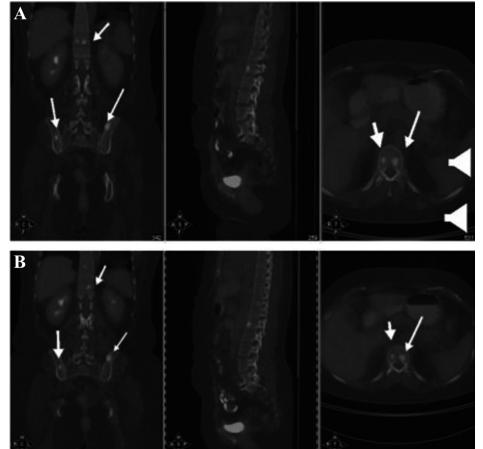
A: PET/CT scan taken at the time of presentation shows bone nodules (vertebrae and iliac bones) which do not show 18F-FDG uptake. B: PET/CT scan taken after about ten months from treatment shows that nodules unchanged.
